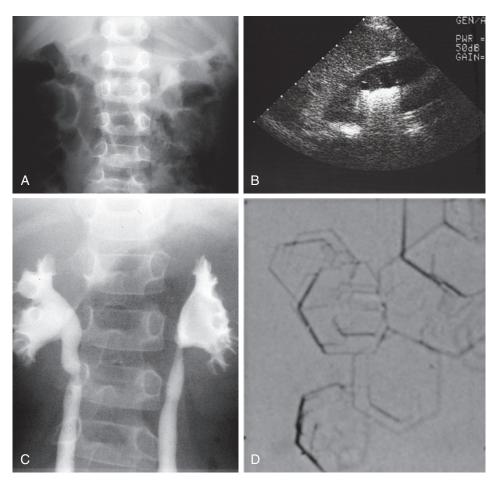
A 6-year-old boy, born of a consanguineous marriage, presented with diffuse abdominal pain, oliguria, and mild renal failure. A, Plain film of the abdomen showed a slight opacity in the area of the left kidney. B, Renal ultrasound demonstrated a distinct shadow produced by the calculus. C, An intravenous pyelogram showed the relatively radiolucent stone within the left renal pelvis. Multiple small calculi produced the dilation and partial obstruction of both ureters. D, The pathognomonic flat hexagonal crystals found in the urine aided in the diagnosis of cystinuria.
